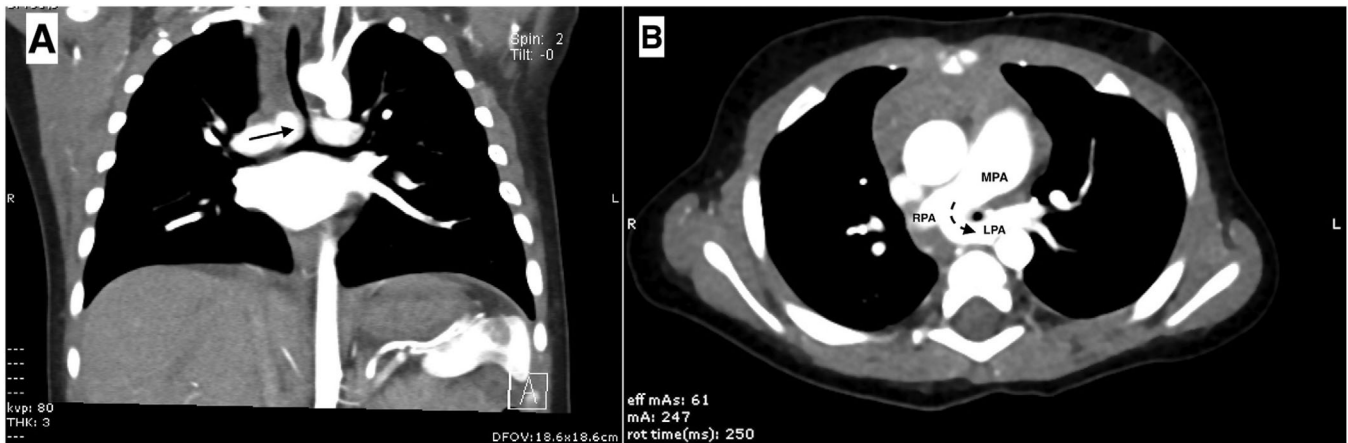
CT angiogram of the chest demonstrating (A) tracheal narrowing. The caliber of the distal trachea (arrow) is noted to be smaller than the left and right main bronchi, resulting in obstructive physiology. (B) Coming off the main pulmonary artery (MPA) are the right pulmonary artery (RPA) and the left pulmonary artery (LPA). The left pulmonary sling (dashed arrow) can be seen coursing around the narrowed trachea (measuring only 2.5 mm in diameter at that point)
